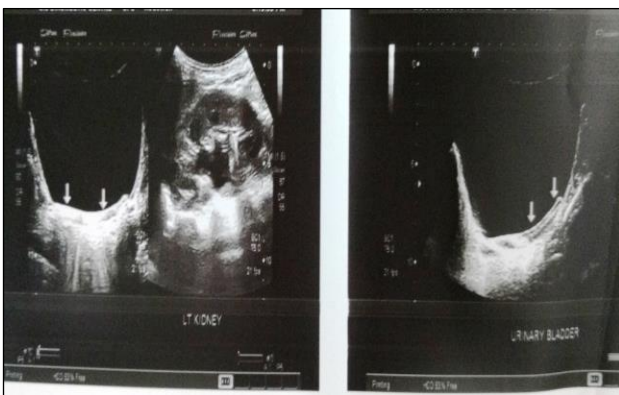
Ultrasound pictures.
